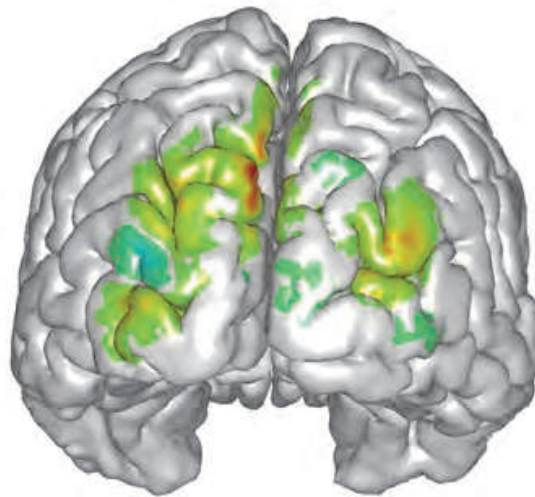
Atlas map visualization of an MRI-guided optical reconstruction of the brain activation in the visual cortex (the brain is seen from the back), during a pattern reversal checkerboard protocol.
